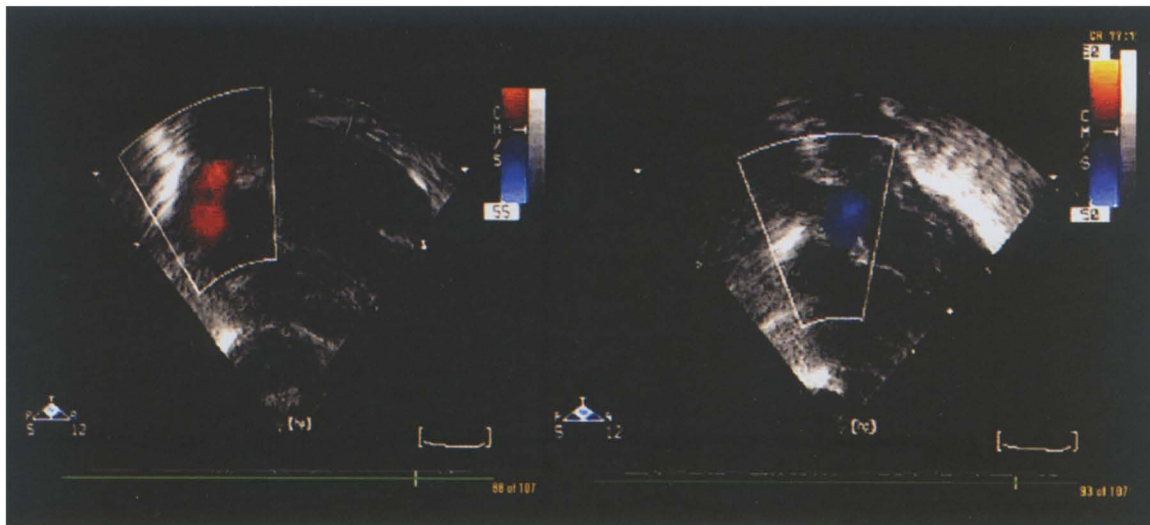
Echocardiogram showing right to left shunt at the ductus arteriosus (right) and reversal of the shunt (left) shortly after iNO administration.
